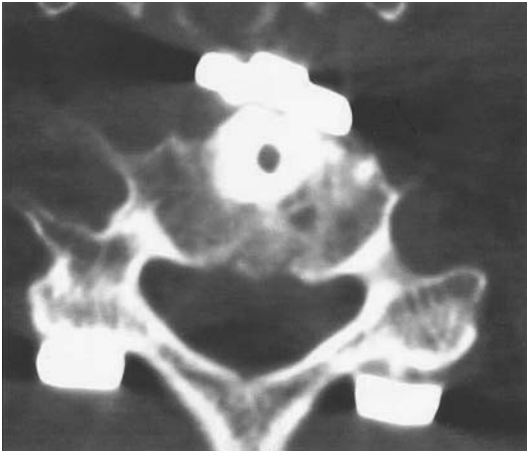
The same patient as in [Fig. 8](#), 2 years postoperative CT scan demonstrating incorporation of fibular graft without creeping substitution.
